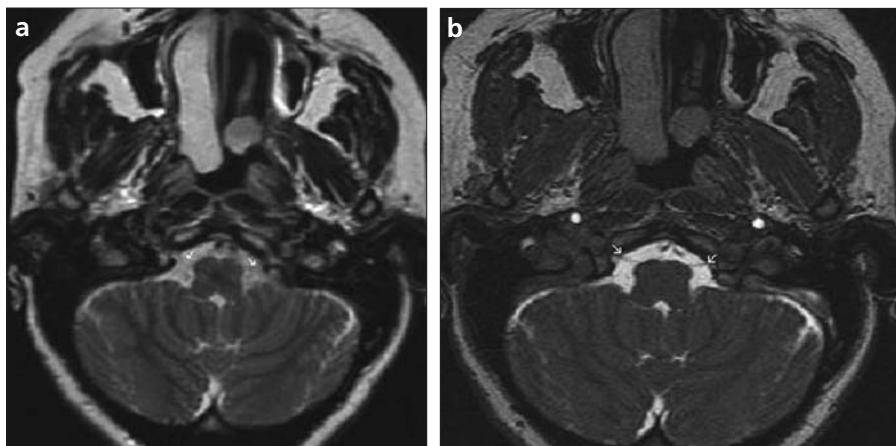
a, b. Cranial nerve XII. On axial FSE T2W MR image (a) cranial nerve XII cannot be evaluated. On axial 3D FIESTA MR image (b), however, it can be clearly visualized (arrows in a and b).
